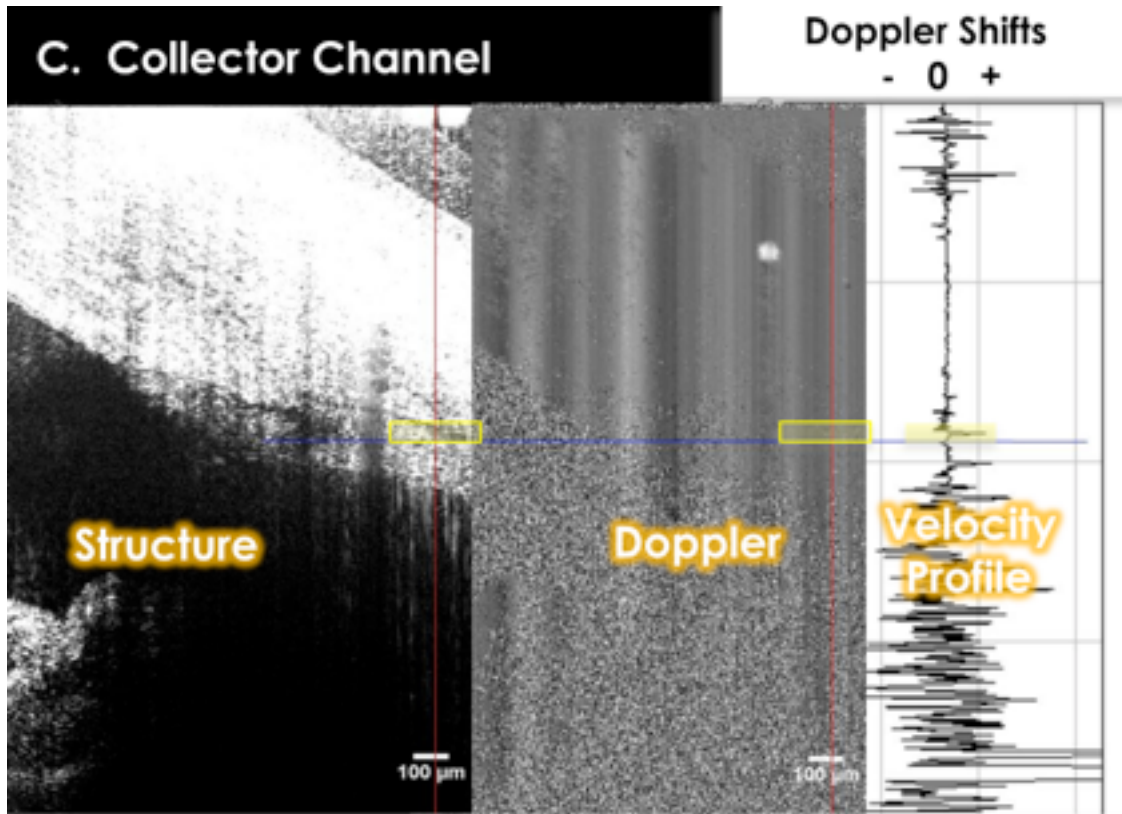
SD-OCT scan location and side-by-side structure and Doppler
